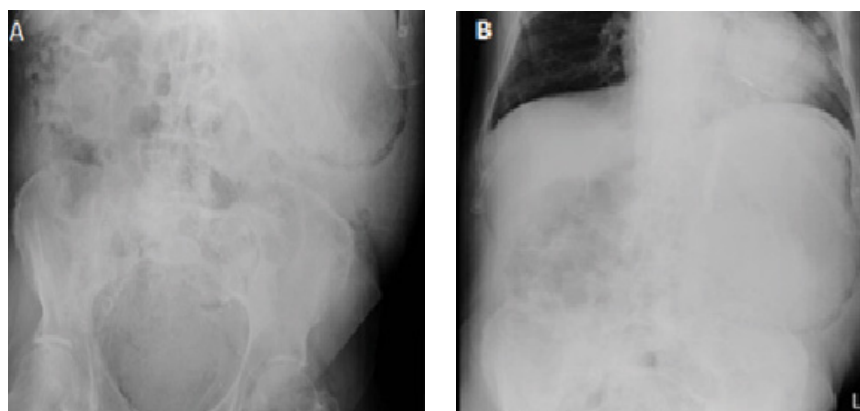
Abdominal radiographs showing: (A) linear gas pattern in upper right abdomen; (B) gas is seen in a projection of greater stomach curvature
